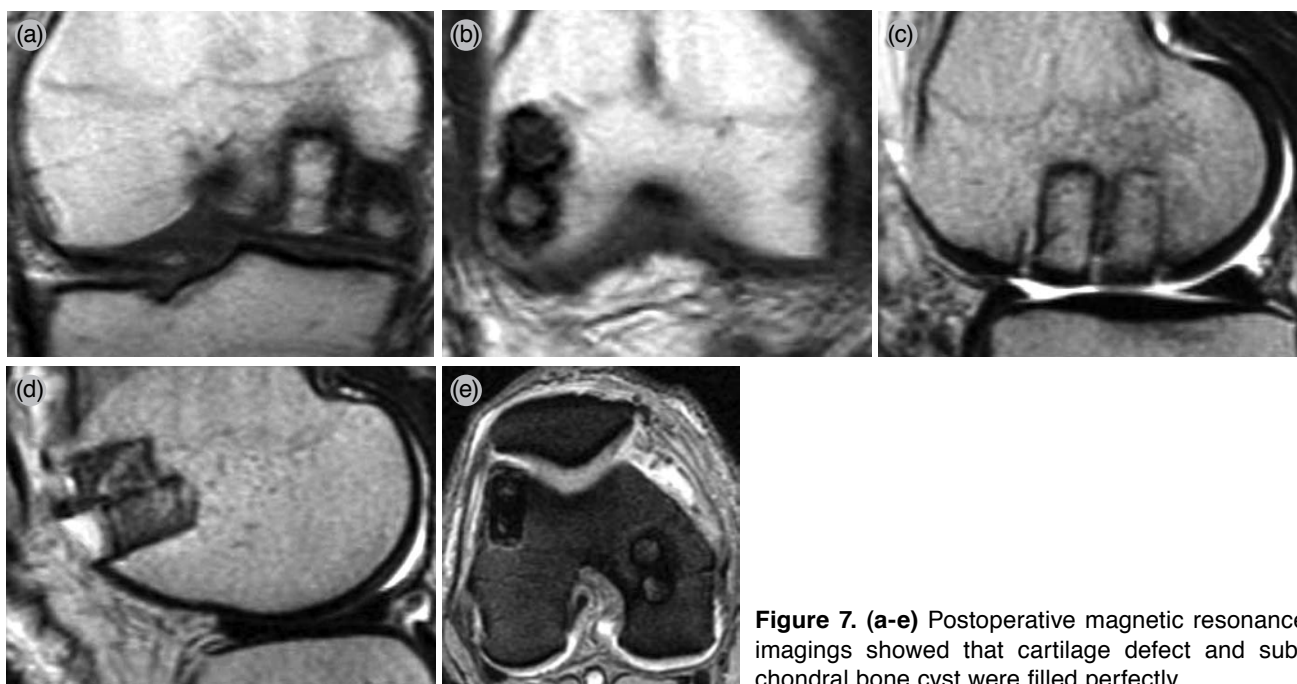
(a-e) Postoperative magnetic resonance imagings showed that cartilage defect and subchondral bone cyst were filled perfectly.
